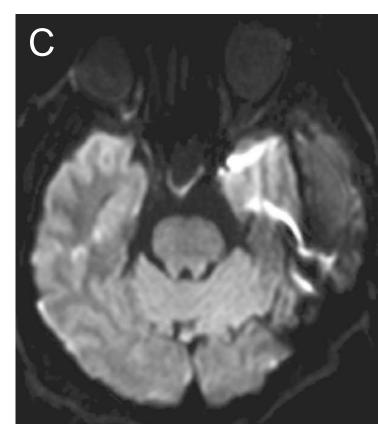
A) Post-operative day 1 axial CT image after evacuation of debris within temporal bone cavity. A Penrose drain is in the cavity. B) 3-month post-operative axial CT image showing no significant regrowth of ground glass lesions. C) 6-month post-operative axial MR diffusion-weighted imaging showing no cholesteatoma recurrence.
